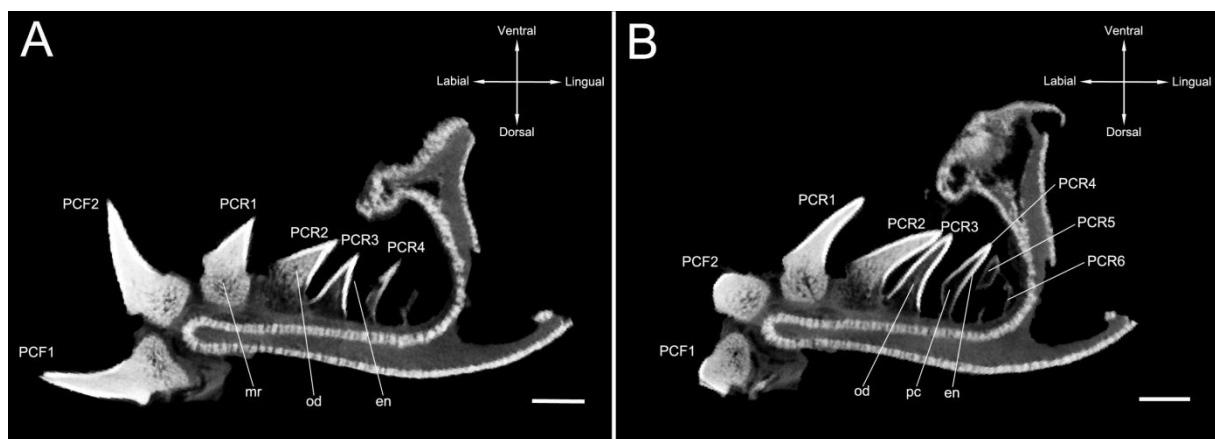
2D digital CT scans from the lower jaw of *Lamna nasus*. Tooth file showing the number of teeth, teeth stages and development. Scale bar = 0.5 cm. en, enameloid; mr, mineralized root; od, osteodentine; pc, pulp cavity.
